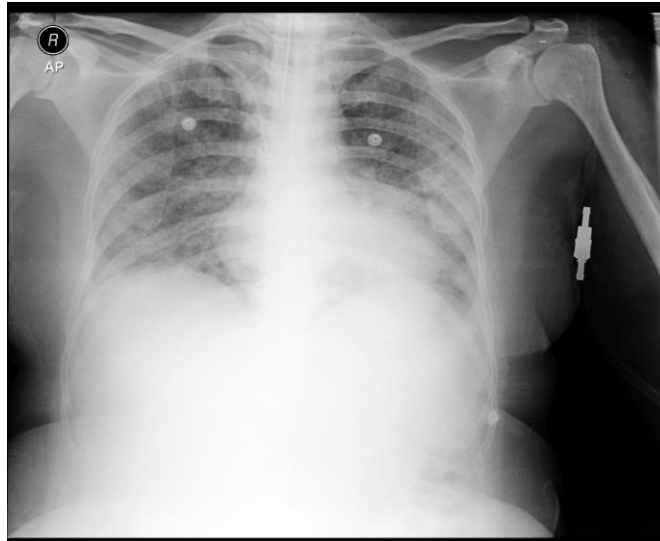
Chest X-ray evaluation showed reduced pneumonia infiltrates.
